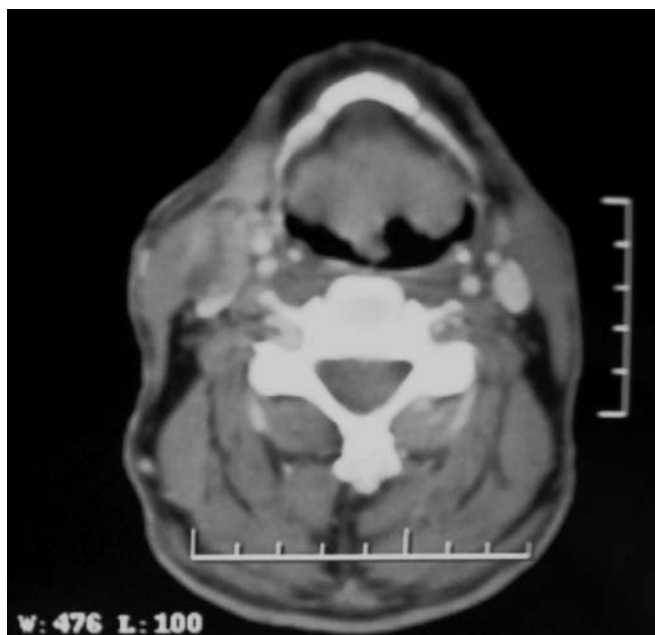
Preepiglottic space infiltration and cervical lymphadenopathy in CT.
